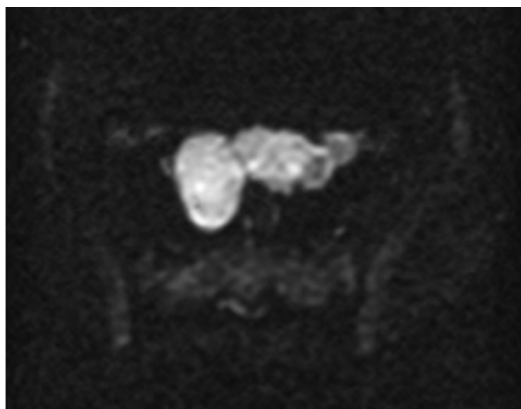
DWI. Axial plane. Endometrium carcinoma staging. Note adnexal bilateral invasion presenting with high SI.
